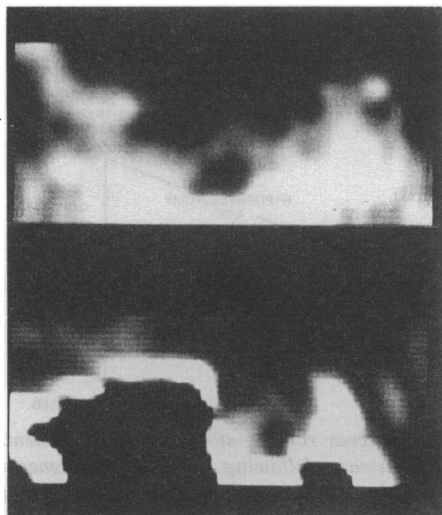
Typical appearance of a pituitary microadenoma in thin collimation CT scan reformations, documented by the findings in a 46-year-old female patient. The region of diminished alteration ('low density zone') is highly suspicious of a microadenoma, confirmed by surgery in this case. The normal pituitary appears to be hyperdense in relation to the adenoma (diameter at operation = 7 mm)
